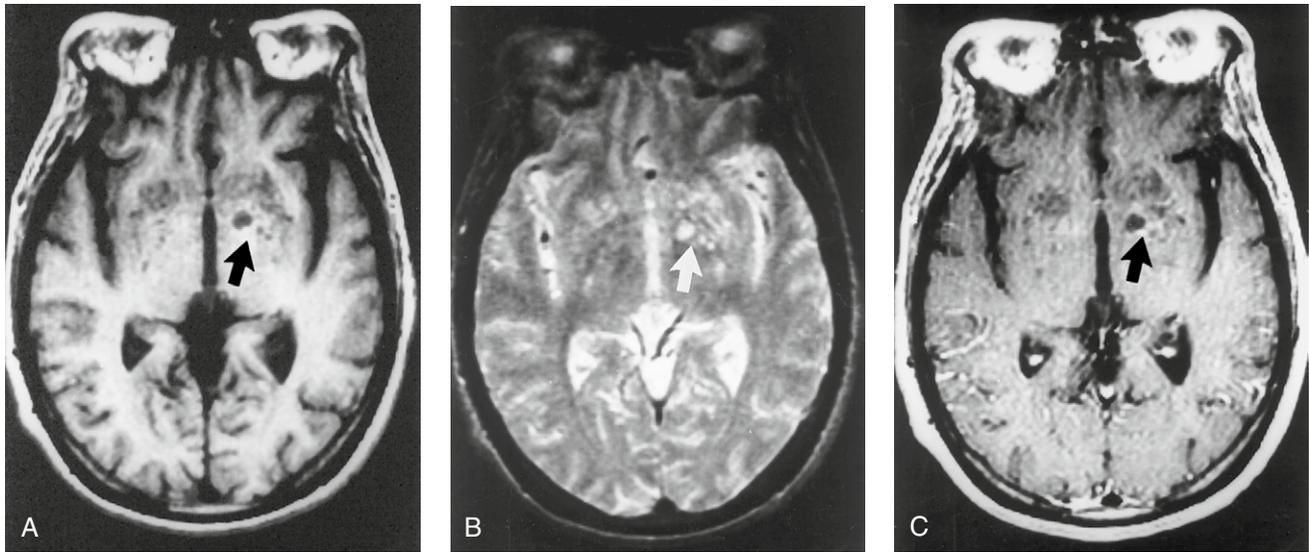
Cryptococcal gelatinous pseudocysts. (A) Axial T1-weighted image shows hypointense dilated Virchow-Robin spaces (*arrow*), gelatinous pseudocysts. (B) Axial T2-weighted image shows hyperintense dilated Virchow-Robin spaces (*white arrow*). (C) Axial T1-weighted image with gadolinium shows minimal enhancement of the gelatinous pseudocysts (*arrow*).
